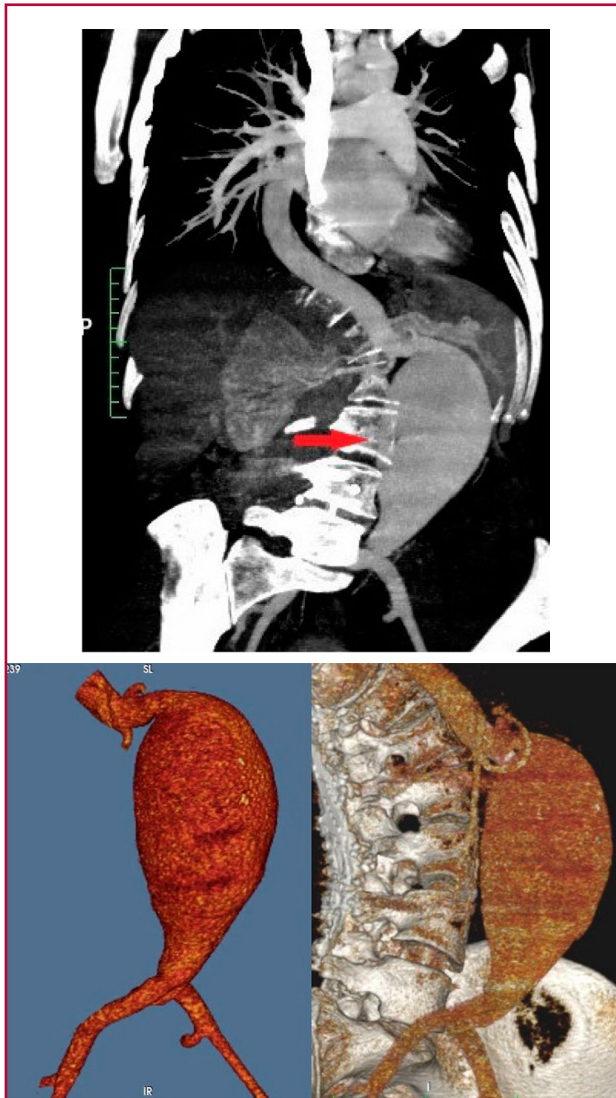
A & B. CT angiography showing infrarenal abdominal aortic aneurysm of 77 mm with no mural thrombus and normal iliac arteries
